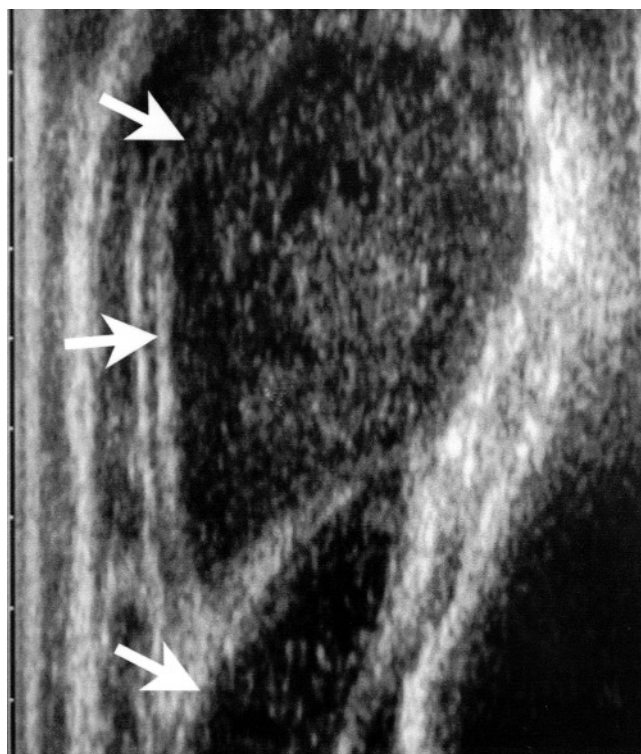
Longitudinal ultrasonography showing heterogeneous fluid collection in the suprapatellar bursa (upper arrows) and a thickened synovial membrane plica (lower arrow).
